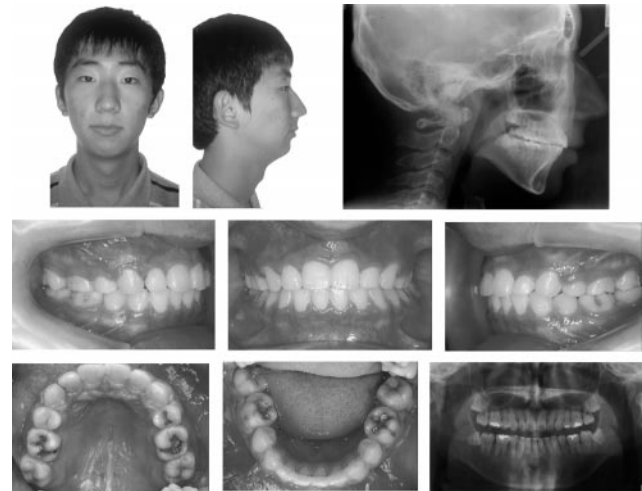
Posttreatment cephalograph, extraoral and intraoral photographs, and panoramic radiograph (case 3).
